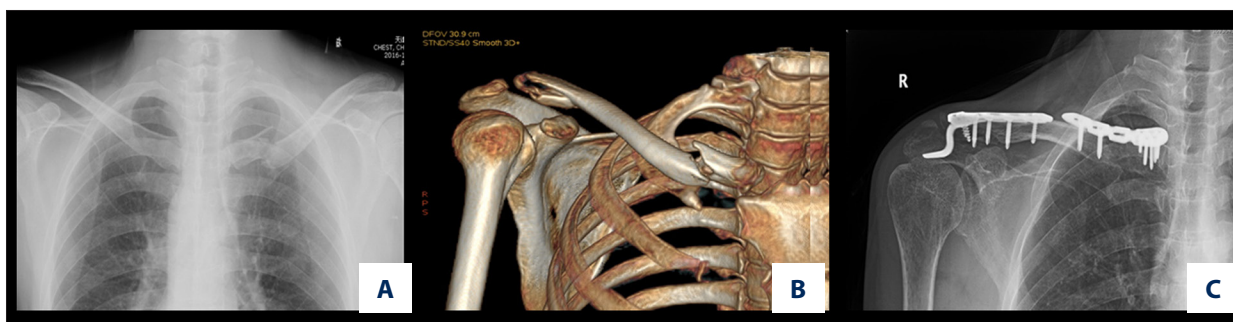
A 38-year-old male had ipsilateral medial clavicle fracture and lateral clavicle fracture. (A) X-ray of the clavicle before surgery. (B) Computed tomography image of the right shoulder girdle showing displaced medial fracture and lateral fracture of the clavicle. (C) The medial clavicle fracture was fixed with reversed lateral locking clavicle plate, and the clavicle fracture was fixed with a hook plate.
